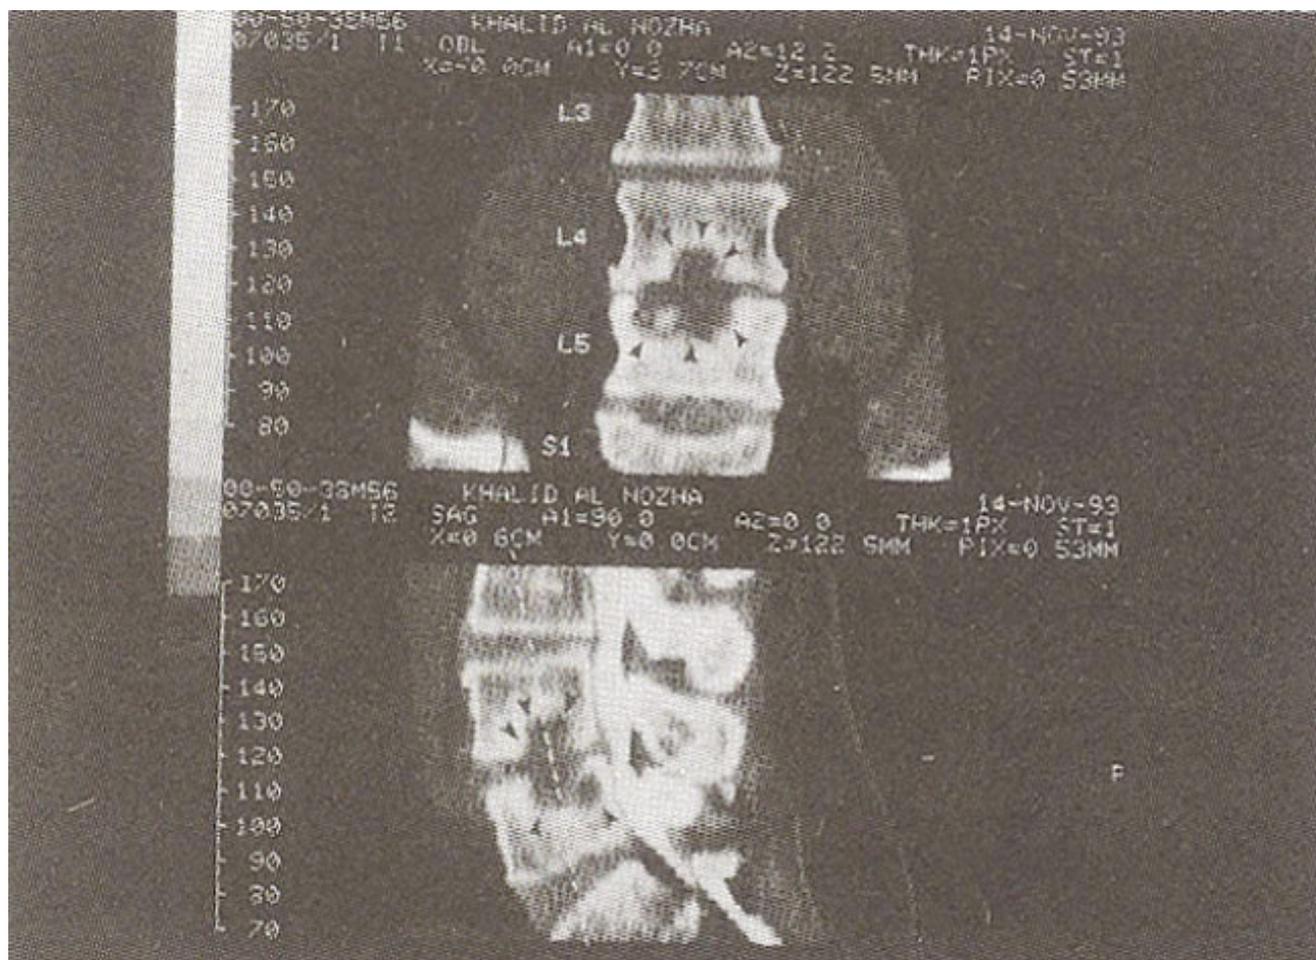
CT-myelography coronal and sagittal reconstruction showing typical picture of discitis. Note the destruction beginning in the disc and spreading to the lower half of the body of L4 and upper half of the body of L5 (arrow heads).
